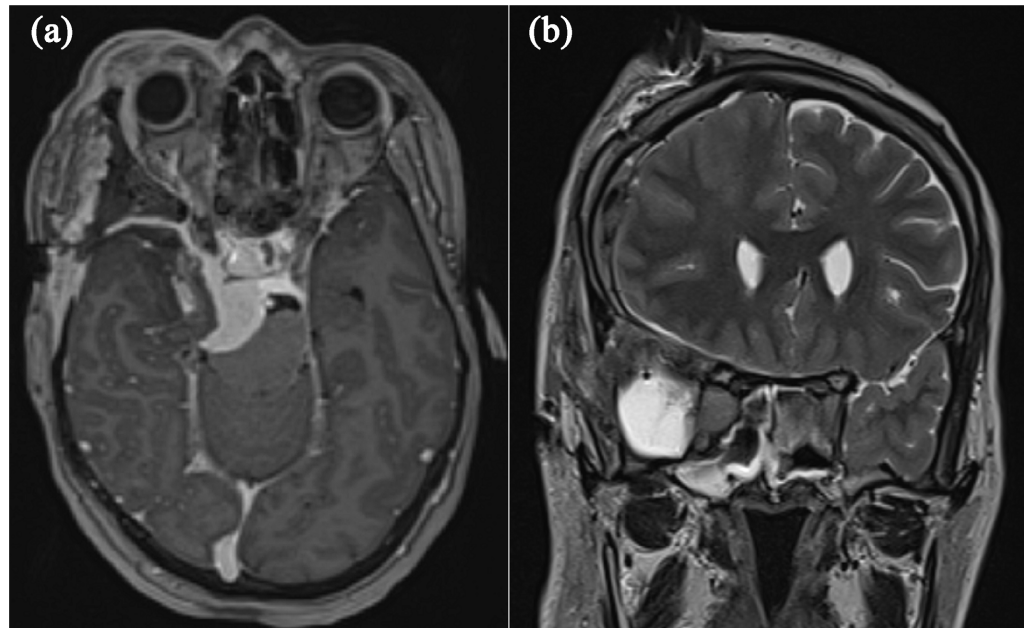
Postoperative cerebral MRI axial (a), coronal slice (b) revealed a remnant of the tumor, a right caverno-petrol-clival meningioma with postoperative changes.
